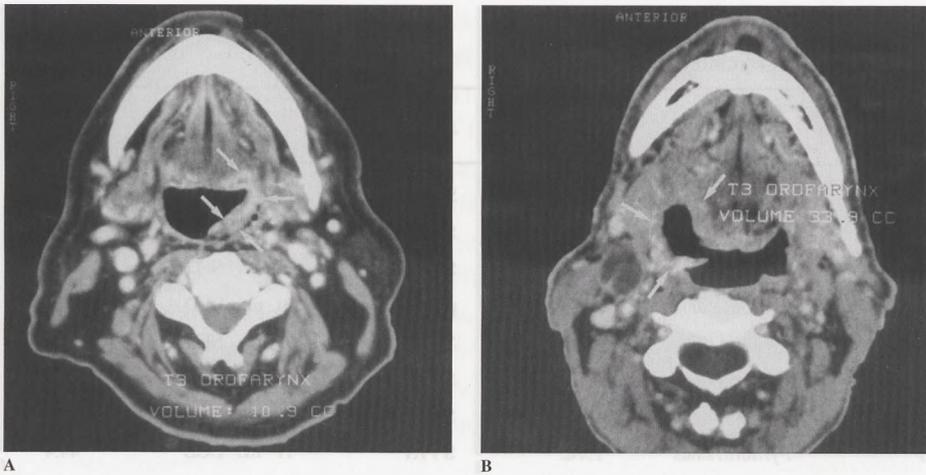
CT axial sections of two different patients with T3 oropharyngeal (tonsillar) carcinoma showing difference in tumor volume of > 100%. (A) Relatively small mass, protruding into the oropharynx (straight arrows); total volume = 10.9 cm³. (B) Large tumor process involving the right oropharynx (straight arrows); total volume = 33.9 cm³.
